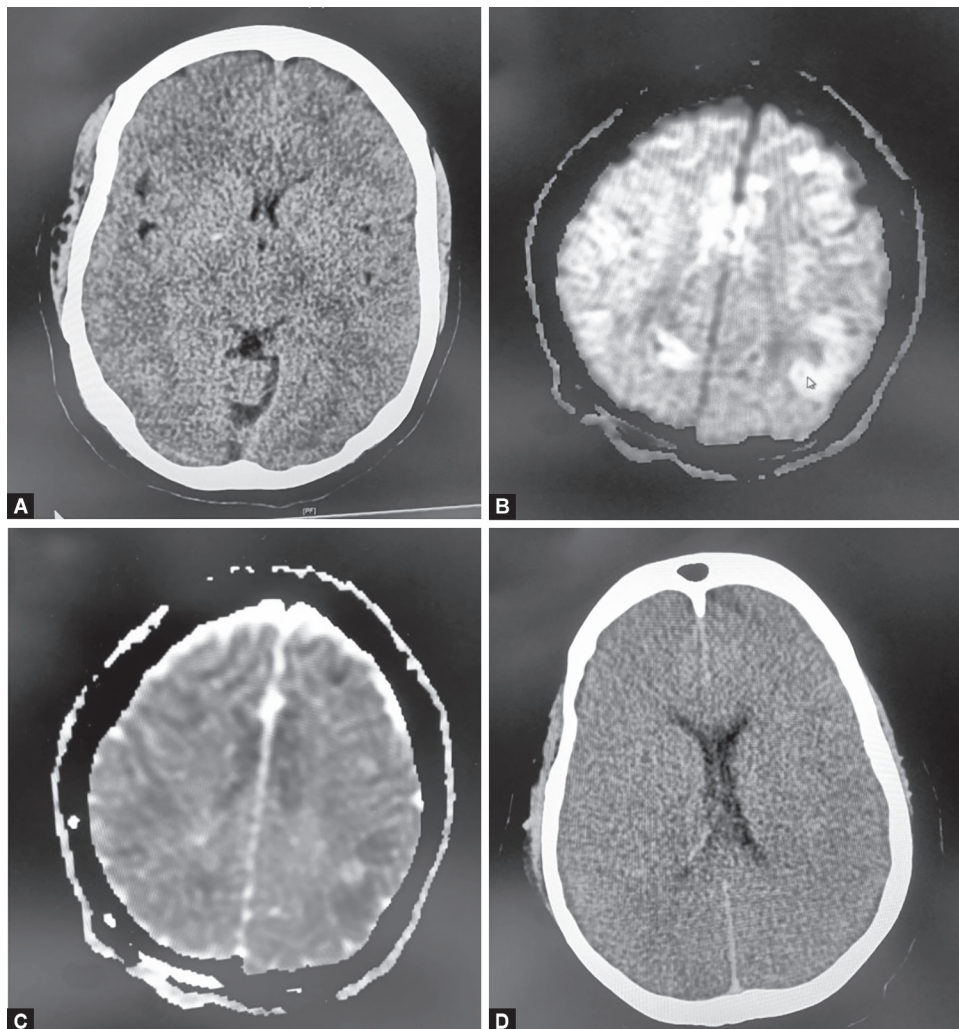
(A) CT scan image of Case 1 shows tiny lesion at globus pallidus; (B) and (C) MRI image of Case 1 show diffusion and ADC images, respectively, show restrictive diffusion of the cortical and subcortical layer suggestive of cytotoxic edema; (D) CT scan image of Case 3 shows diffuse brain edema
